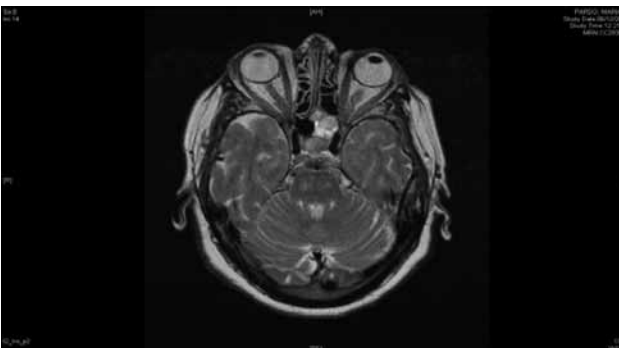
MRI shows a highly vascular tumour in the left ethmoid cavity.*
